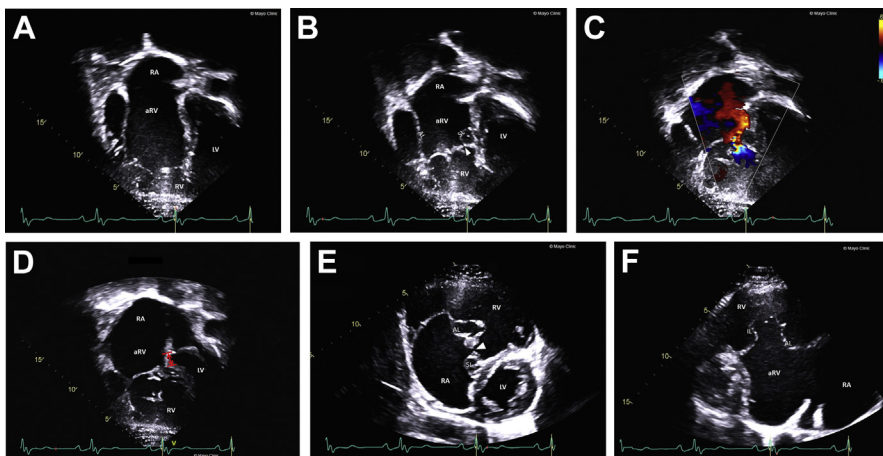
Transthoracic echocardiographic images from a patient with Ebstein anomaly. Apical 4-chamber view (apex down format) in diastole (A), systole (B), and color Doppler (C), showing severe right heart enlargement, apical displacement of the septal leaflet, tethering of the anterior leaflet, coaptation defect (B [arrowhead]) and the origin of tricuspid regurgitation (C). (D) Measurement of apical displacement of the septal leaflet in a modified apical 4-chamber view. (E) Parasternal short axis view at the midventricle showing large, tethered anterior leaflet and rudimentary septal leaflet with coaptation defect (arrowhead). (F) Parasternal RV inflow view demonstrates anterior and inferior leaflets. AL, anterior tricuspid valve leaflet; aRV, atrialized right ventricle; IL, inferior tricuspid valve leaflet; LV, left ventricle; RA, right atrium; RV, right ventricle; SL, septal tricuspid valve leaflet.
